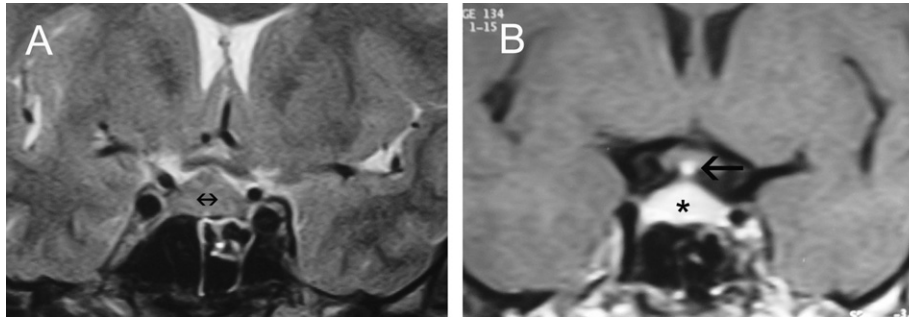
Preoperative coronal MRI. (A) T2-weighted image without contrast and (B) diffuse pathological enhancement on T1-weighted image with contrast *. Note the thickening of the pituitary stalk and enhancement with contrast material (arrow).
